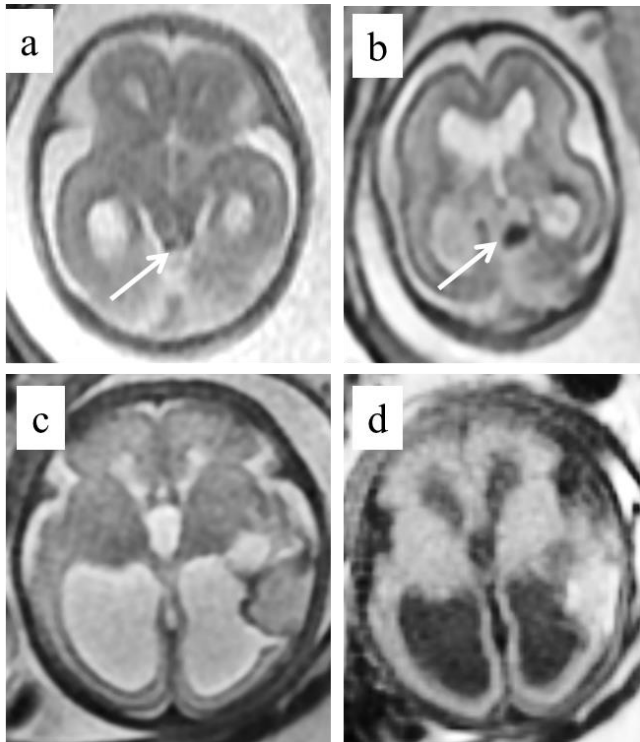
Recurrent, multifocal haemorrhagic stroke. A fetus was shown to have mild ventriculomegaly on ultrasonography at 21gw. Axial T2-weighted images at 22gw fetus (4a and 4b) confirm ventriculomegaly and show a low signal mass related to the tectal plate and extending into the pineal cistern (arrowed on 4a and 4b). This was thought to represent hemosiderin related to either earlier haemorrhage or a cavernoma. The fetus had a further iuMR study at 30gw because of increasing ventriculomegaly. Axial T2-weighted (4c) and FLAIR (4d) confirm severe ventriculomegaly and show a new intra-parenchymal haematoma in the left temporal lobe. No specific cause was discovered.
